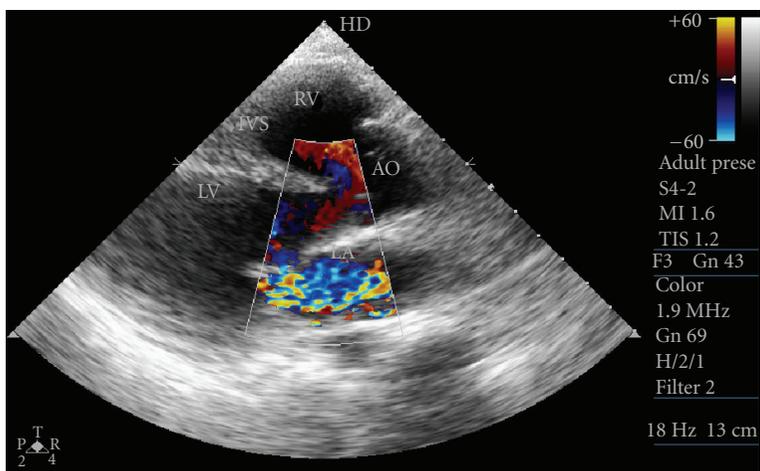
Parasternal long axis view depicting nonrestrictive VSD with moderate to severe mitral regurgitation.
